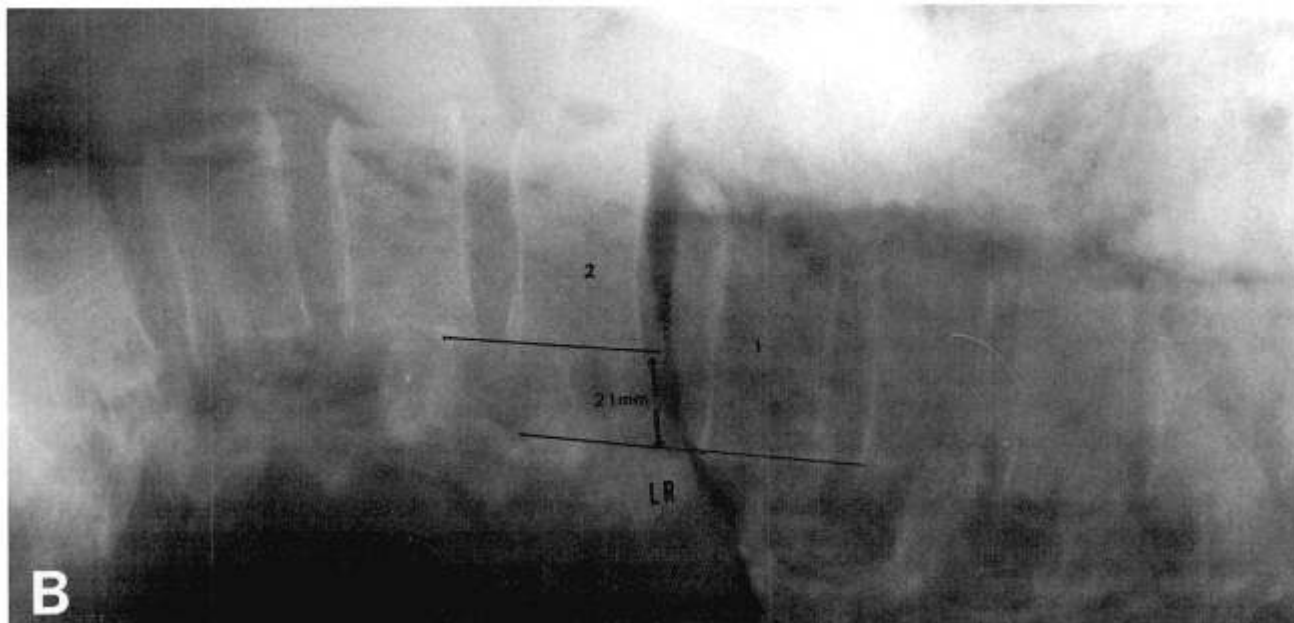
Lateral radiograph of the spine taken during the log-roll maneuver reveals an anteroposterior displacement of 21 mm. The spinal canal is completely occluded with this maneuver.
